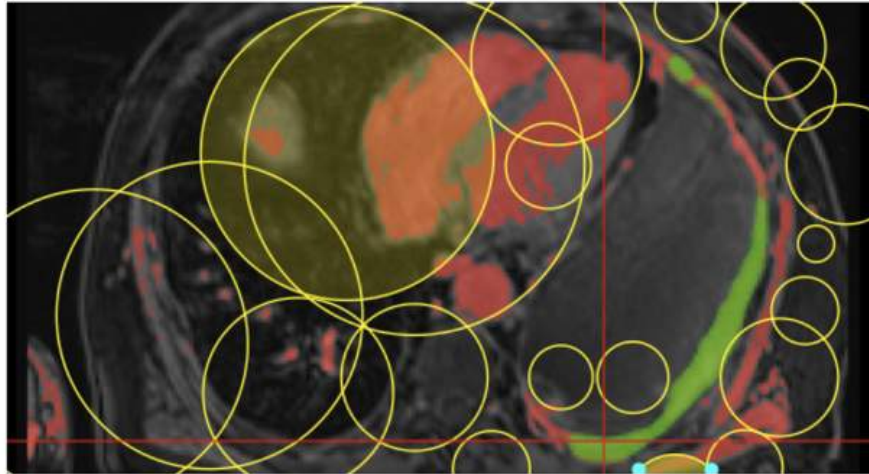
Manual delineation of pleural volume at contrast-enhanced MRI using OsiriX software
